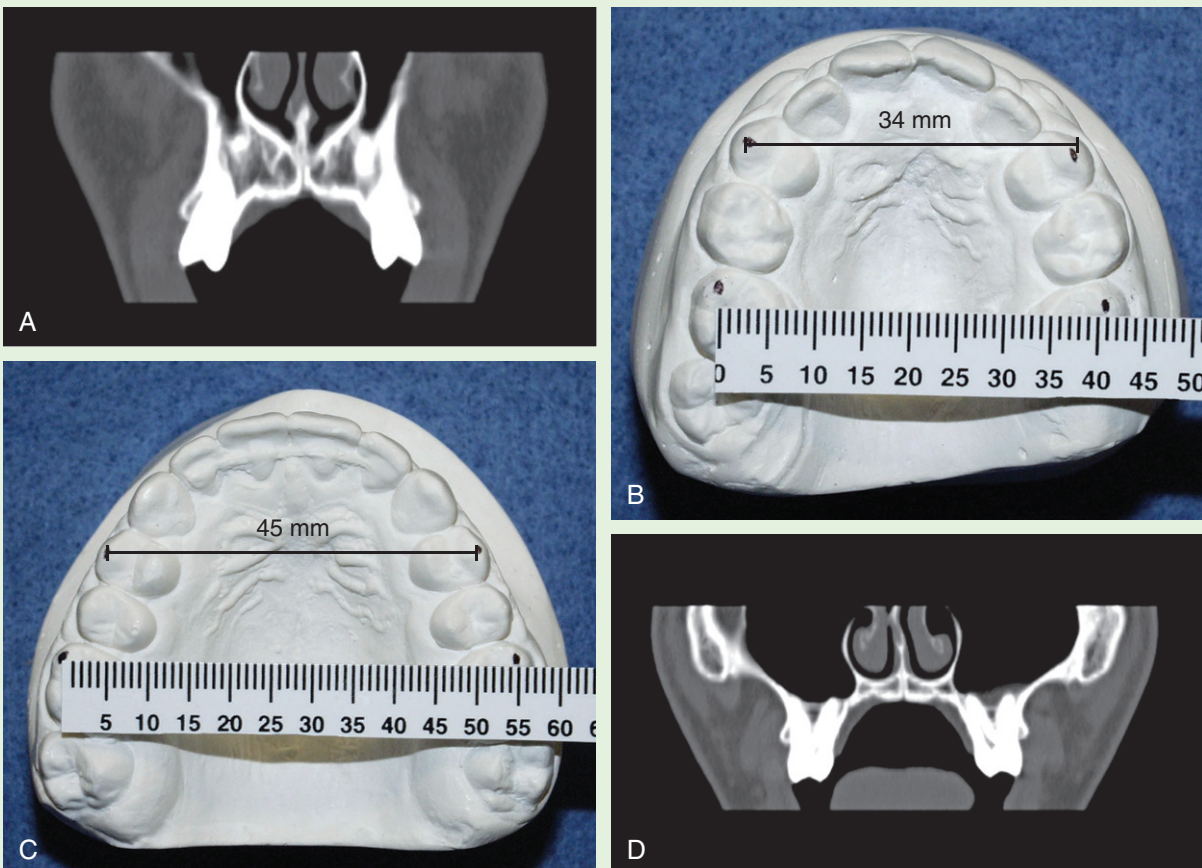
Comparisons of pretreatment and posttreatment upper arch plaster models for CB with computed tomographic scans. Pretreatment and posttreatment plaster models of the upper arch show 11-mm change in first premolar width (and an estimated 12- to 13-mm change in second premolar width) and 14-mm change in first molar width. The bony contours on the buccal of the first premolars and first molars are evident. Vertical scans taken 5 years, 3 months into retention show healthy alveolar bone. A, Scan of upper first premolars at 5 years, 3 months in retention. B, Pretreatment. First premolars: 34 mm; first molars: 41 mm. C, Posttreatment. First premolars: 45 mm; first molars: 55 mm. D, Scan of upper first molars 5 years, 3 months in retention.
